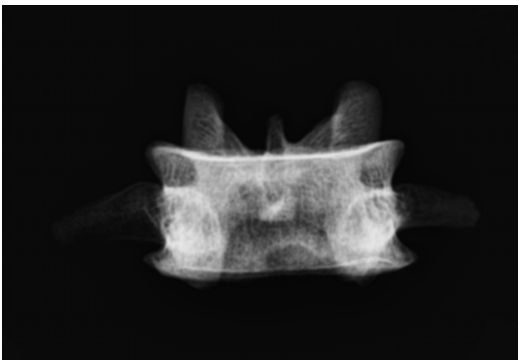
X-rays antero-posterior view of the vertebra show homogeneous radiopacity of the left peduncle
